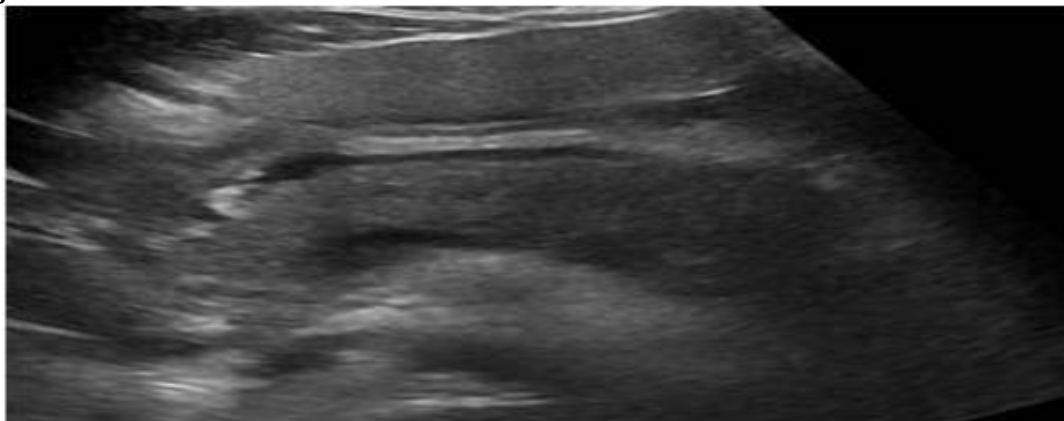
Acute pancreatitis with peripancreatic collection on Ultrasonography
